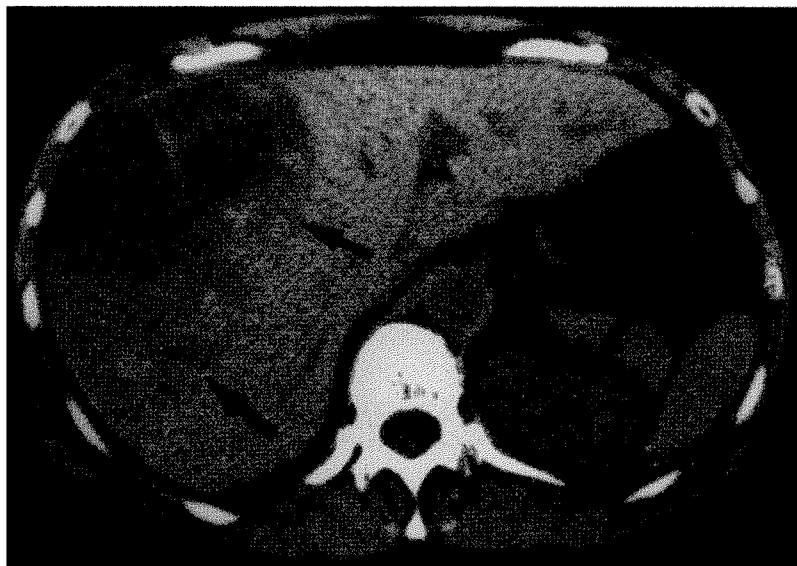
Noncontrast CT scan showing large hepatic hematoma with heterogenous density (arrows).
